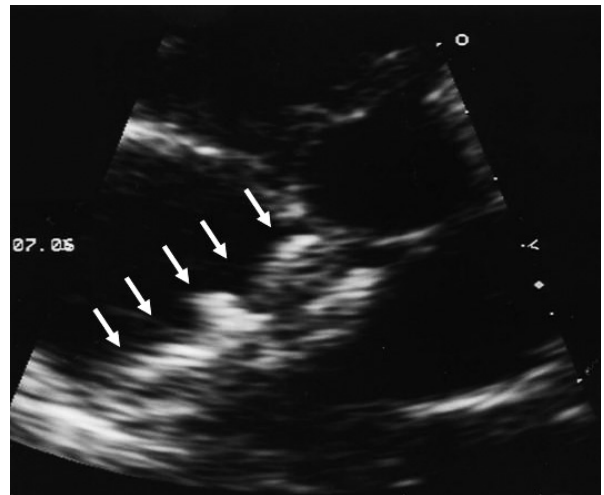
Echocardiogram at the onset of migraine
